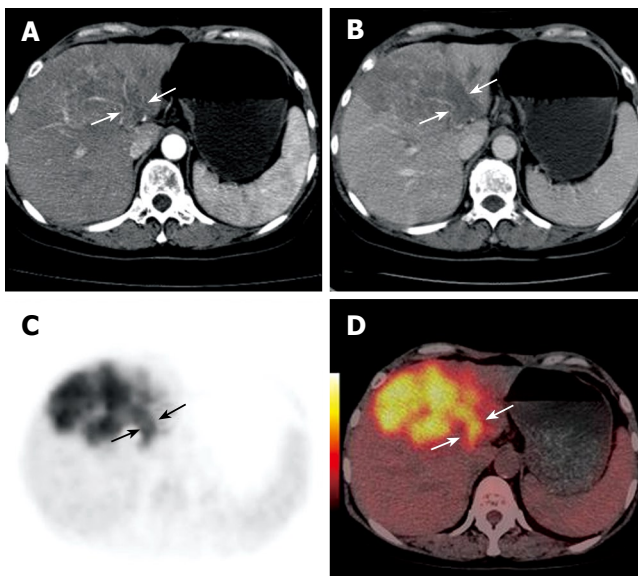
Contrast CT scan demonstrating a left lobe mass and portal vein thrombus in a 60-year-old woman. During the arterial phase, the thrombus appears as a hypodense intraluminal area with dense linear enhancement (white arrows, A). A filling defect was detected in the left branch during the portal phases (white arrows, B). PET (black arrows, C) and PET/CT fused images (white arrows, D) reveal a highly metabolic thrombus in the left branch.
